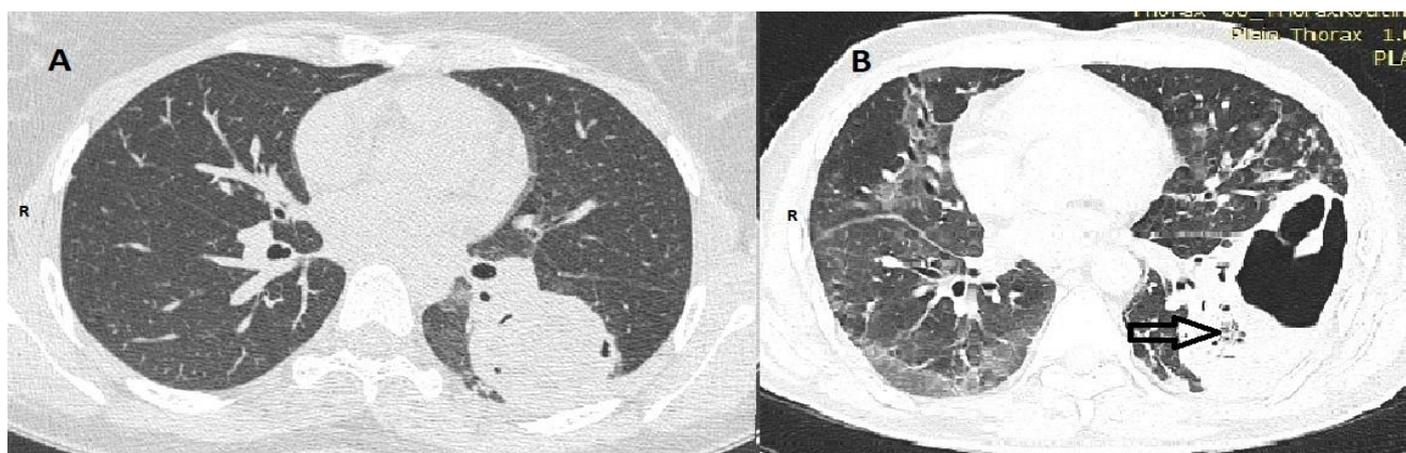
Axial CT scan of chest shows (A) left lower lobe thick-walled cavity (B) Chest CT showed worsening of pulmonary lesion with cavity formation along with area of consolidation surrounding ground glass opacity suggestive of reverse Halo sign (arrow) in left lower zone shown in figure 3B.
